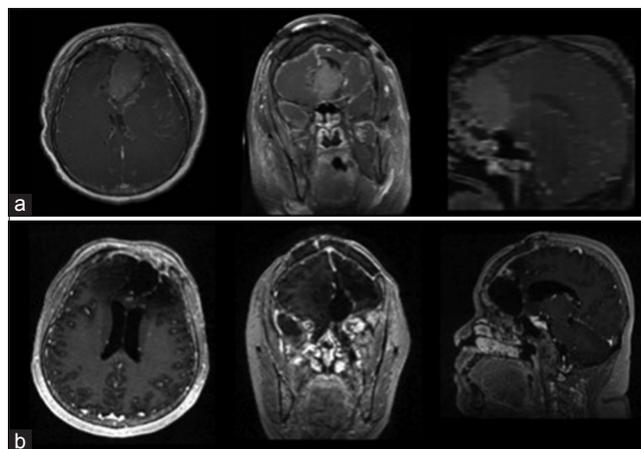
Immediate (a) 1 year (b) postoperative magnetic resonance imaging T1 postcontrast
